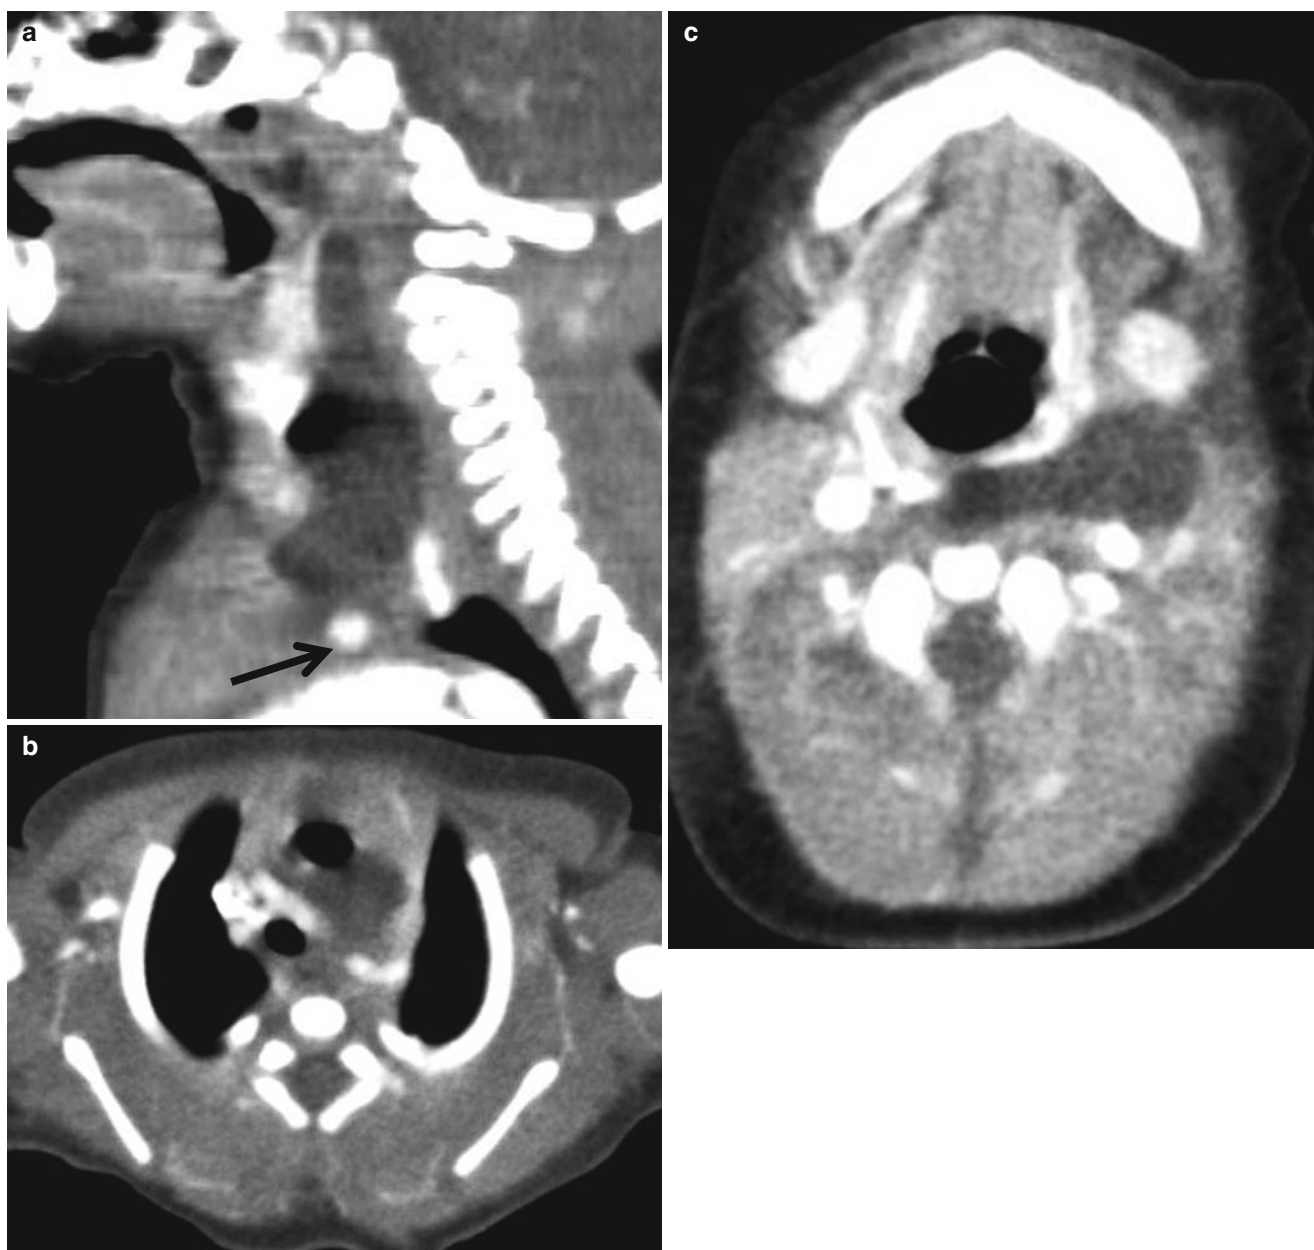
Fourth branchial cleft cyst with a sinus in a 2-day-old neonate. (a) Contrast-enhanced sagittal reformatted CT scan shows a large air-containing elongated cystic mass from the hypopharynx to the level of the aortic arch (*arrow*). Note the motion artifact due to severe
